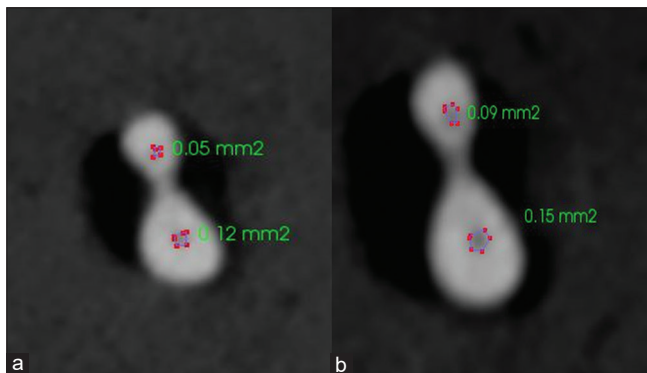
(a and b) Pre- and Post-operative scan calculating area of the canal using cone-beam computed tomography
